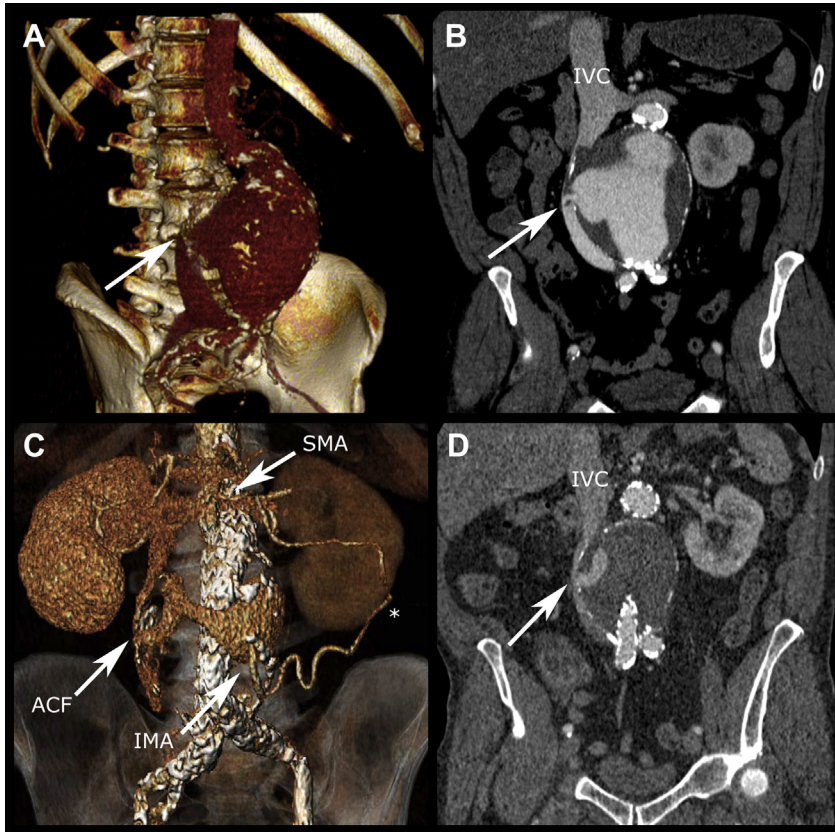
A preoperative (A) luminal three-dimensional reconstruction and a (B) coronal view of the computed tomography angiography (CTA) show a 10-cm large abdominal aortic aneurysm (AAA) with associated aortocaval fistula (ACF, white arrowheads). A postoperative (C) reconstruction and a (D) coronal view show the persistent aortocaval fistula at the 1-year follow-up. *Artery of Drummond; IMA, inferior mesenteric artery; IVC, inferior vena cava; SMA, superior mesenteric artery.
